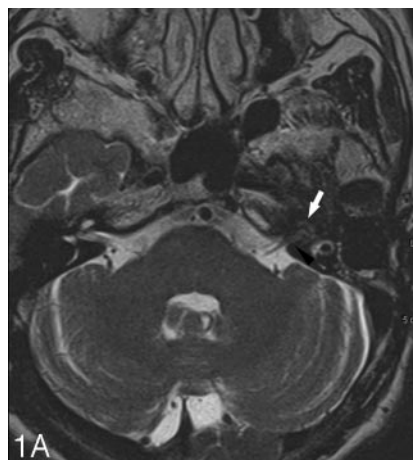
MR images of a patient diagnosed as having aspergillosis involving the left inner ear and IAC. These images were obtained in November 2004.
